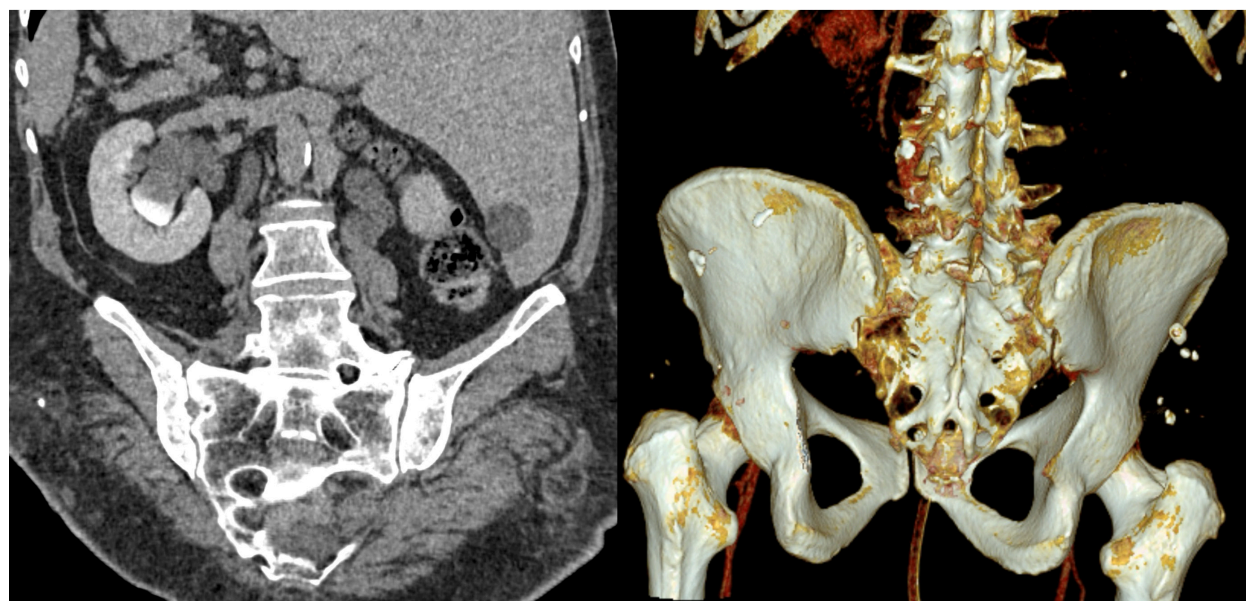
Computed tomography showing a transitional vertebra at L5, with enlarged transverse processes at L5.
